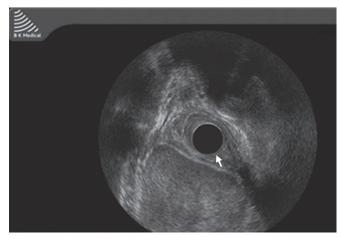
Endorectal ultrasound (showing a mass suggestive of sarcoma or a duplicated cyst)
